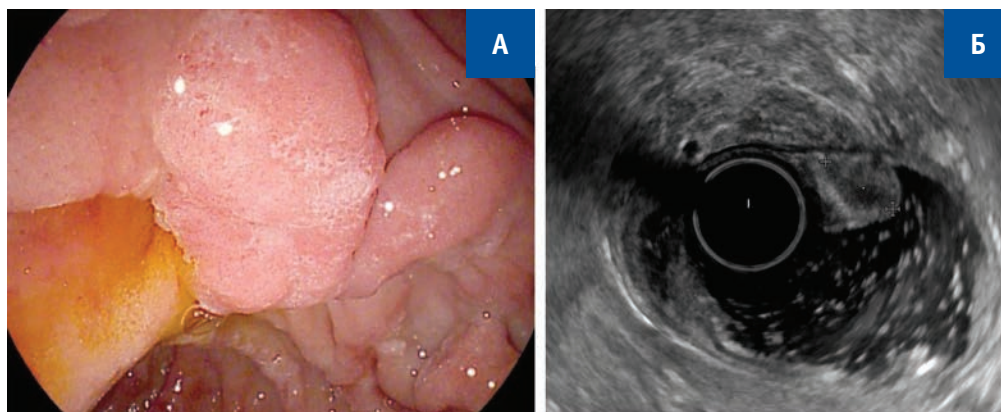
A — duodenoscopy: MDP adenoma with infrapapillary spread to the intestinal wall; B — endosonography: no signs of adenoma spreading to the terminal sections of the ducts
